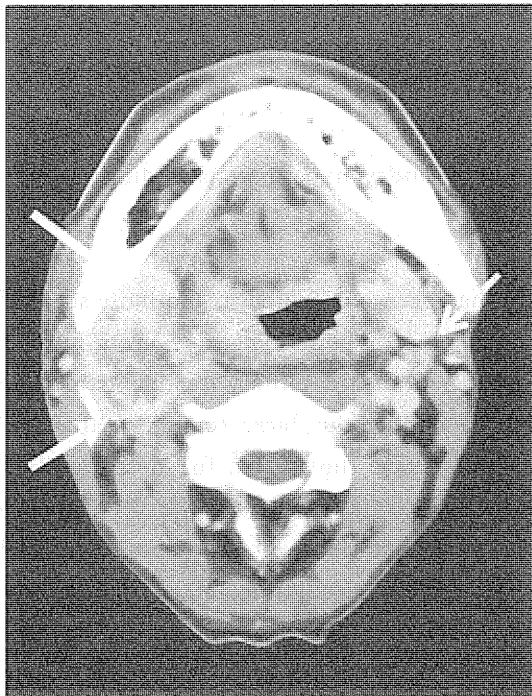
X-ray CT scan shows a right upper deep cervical metastatic node with an extracapsular extension (→). The primary hypopharyngeal tumor extends up to the right mesopharyngeal wall (*). On the left upper deep cervical region, small but irregularly enhanced nodes (→) were also detected.
